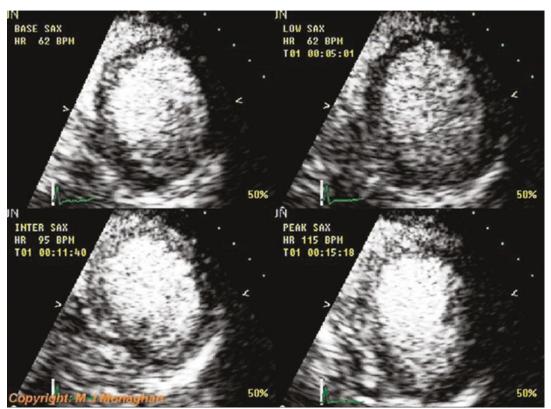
Using low MI imaging, contrast attenuation is minimised and so parasternal views (as shown here) can usually be used. Good endocardial definition is seen at all
